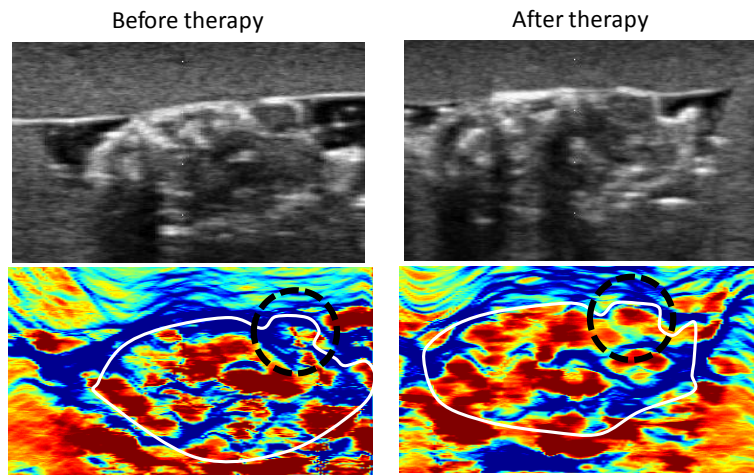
Ultrasound elasticity imaging for accessing photothermal therapeutic outcomes. Black dotted line indicates tumor.
